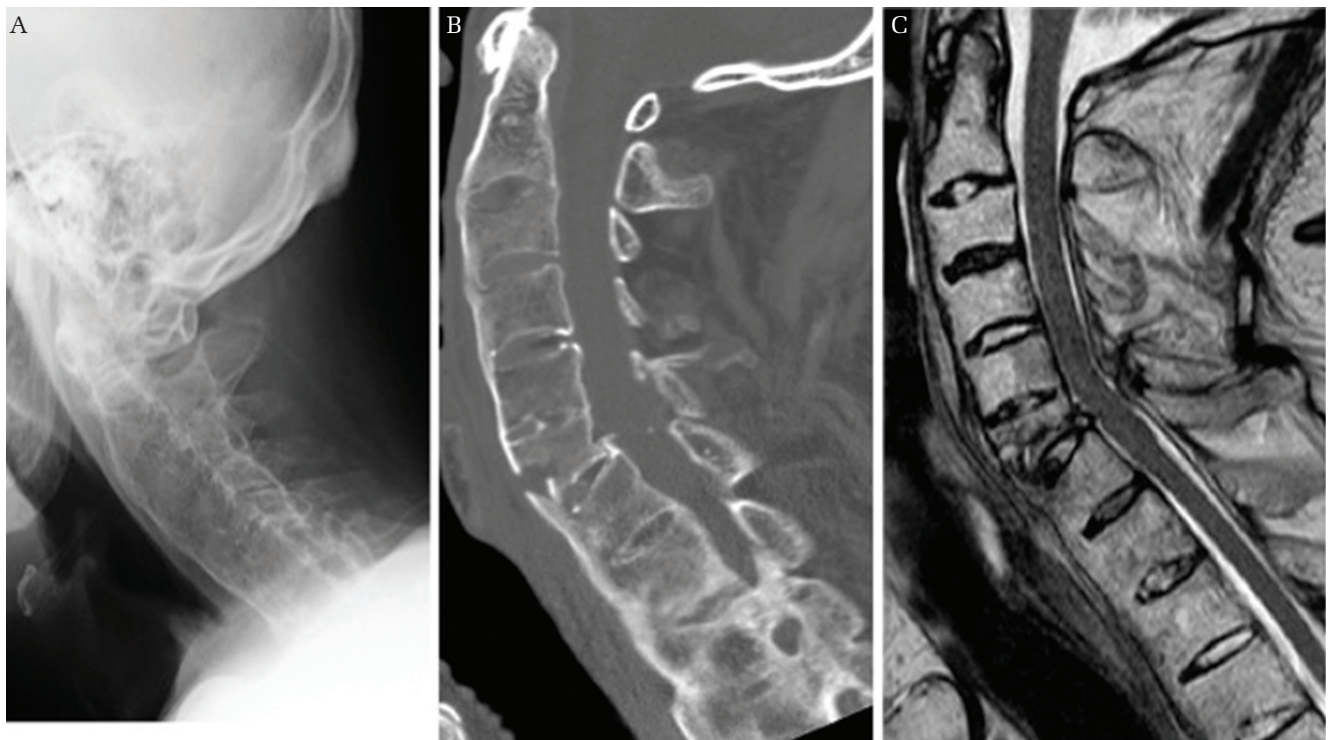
Case 1. Lateral radiography (A) and computed tomography scanning (B) reveal a vertebral fracture of the C6 level, and a magnetic resonance imaging (C) reveals a spinal cord injury at the same level.
